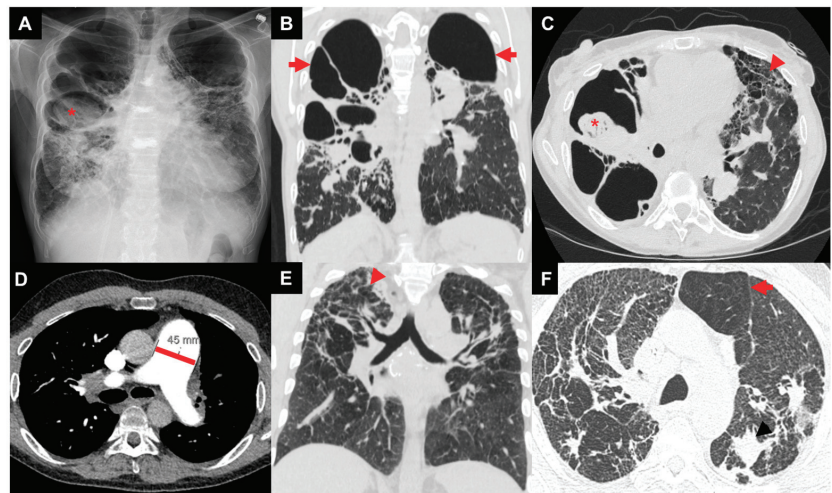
Images of three patients with advanced pulmonary sarcoidosis: patient 1 with biapical cavities and mycetoma (asterisk) on chest X-ray (A), large biapical bronchiectatic cavities (arrows) on coronal image of CT chest (B), right apical mycetoma (asterisk) and extensive left-sided upper-zone predominant fibrosis (arrow head) of anterior lung on axial image of CT chest (C); patient 2 with enlarged pulmonary artery diameter (45 mm) on axial image of CT chest (D); patient 3 with bilateral irregular reticular and nodular fibrosis (arrow head) on coronal image of CT chest (E) with air trapping (arrow) on axial image of CT chest (F).
